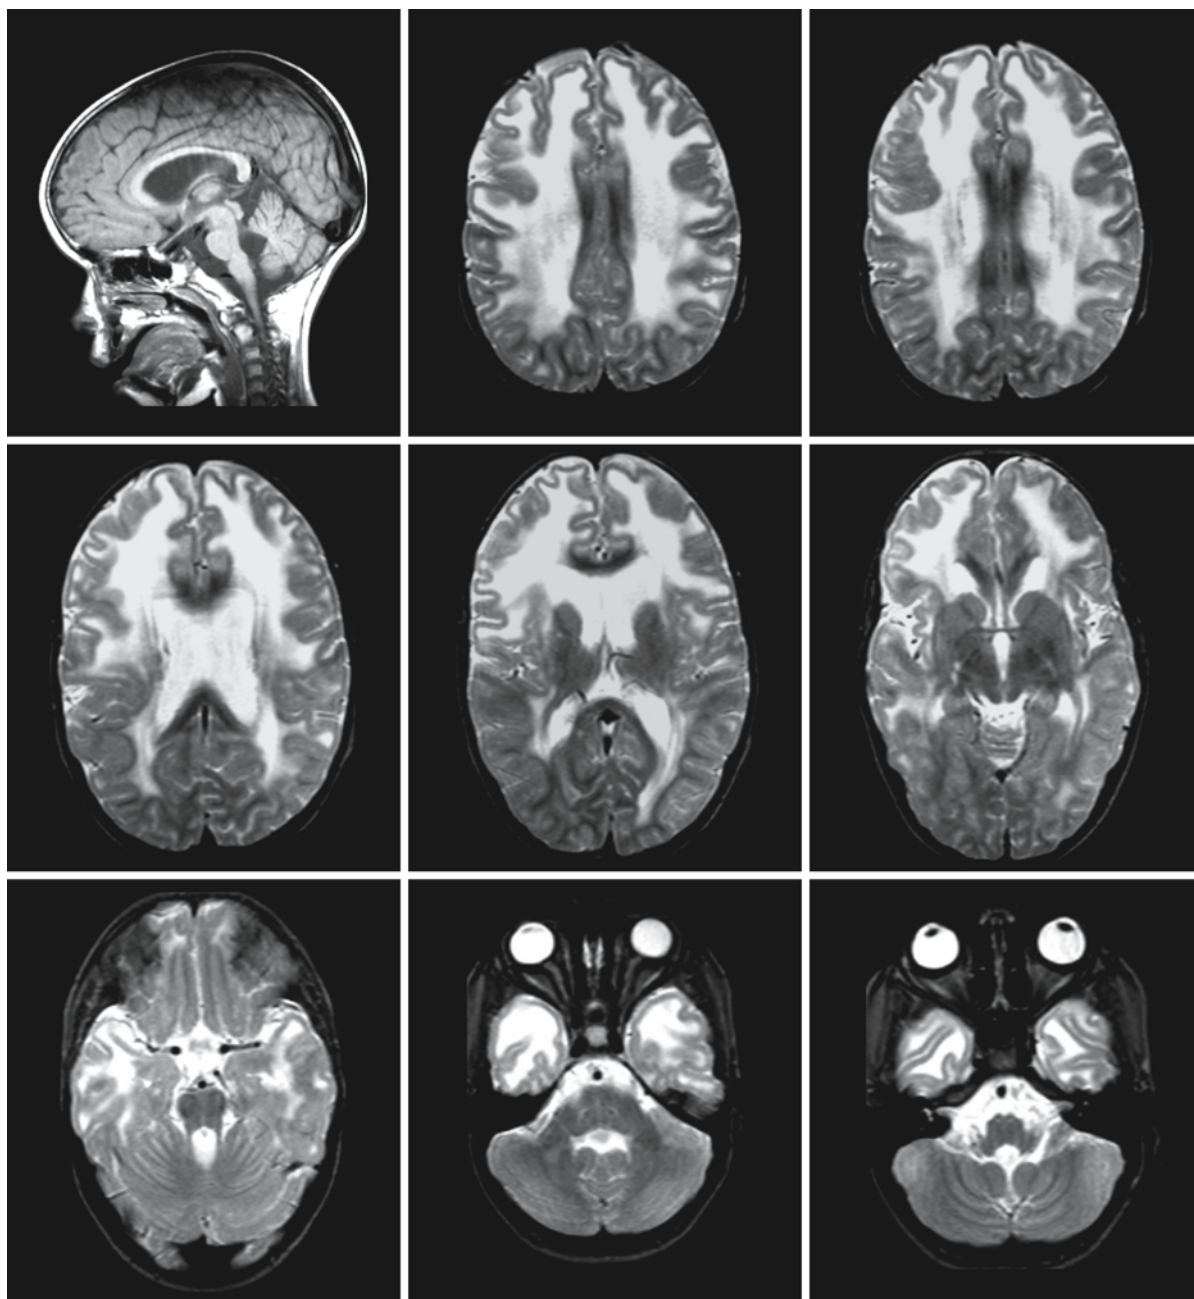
A 6-year-old girl with classical MDC1A. The MRI shows prominent white matter changes. The abnormal white matter is mildly swollen with broadening of the gyri. MRI shows that the cortex is of normal thickness and does not have an irregular border. The frontal white matter is most abnormal
